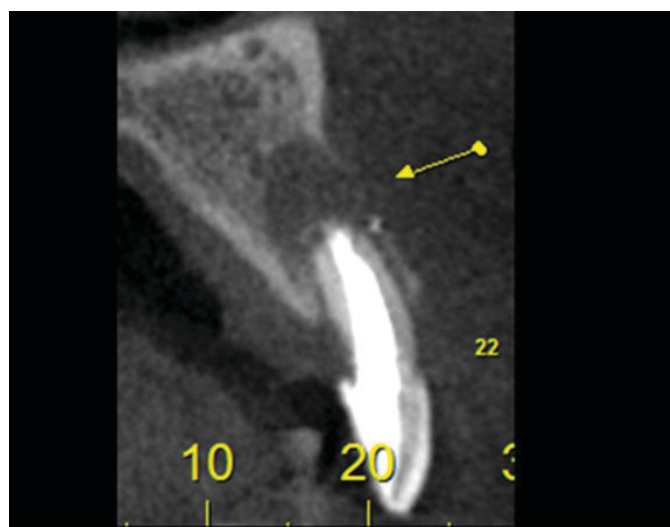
Initial radiographic view.
